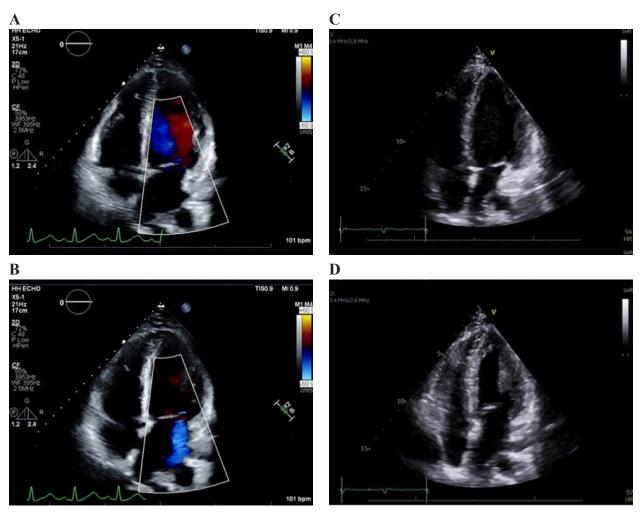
Patient's echocardiograms during admission. Echocardiogram on day 2 (a)(b) in comparison to day 8 (c)(d) of symptom onset. (a) biventricular dilation at day 2 of hospitalization. (b) biventricular systolic dysfunction with LVEF 25-30% along with moderate mitral regurgitation. (c)(d) biventricular failure improved with LVEF of 55% and diminished mitral regurgitation.
